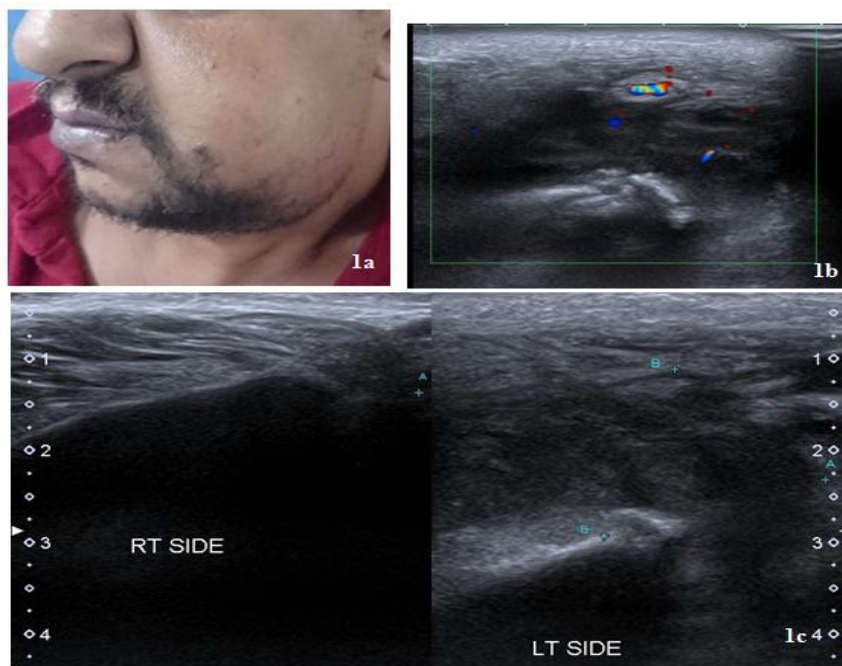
a case of chronic suppurative osteomyelitis, male patient aged 46-year had a painless, hard, unilateral, left sided mandibular swelling with enlarged lymph nodes. (1a) US images revealed large hypoechoic lesion involving the left cheek and mandibular region with heavy internal echoes, edematous surrounding soft tissue and irregular erosion of the underlying mandibular bone. Little vascularity showed on color Doppler mode. The right cheek and mandibular region were normal. (1b&c)
